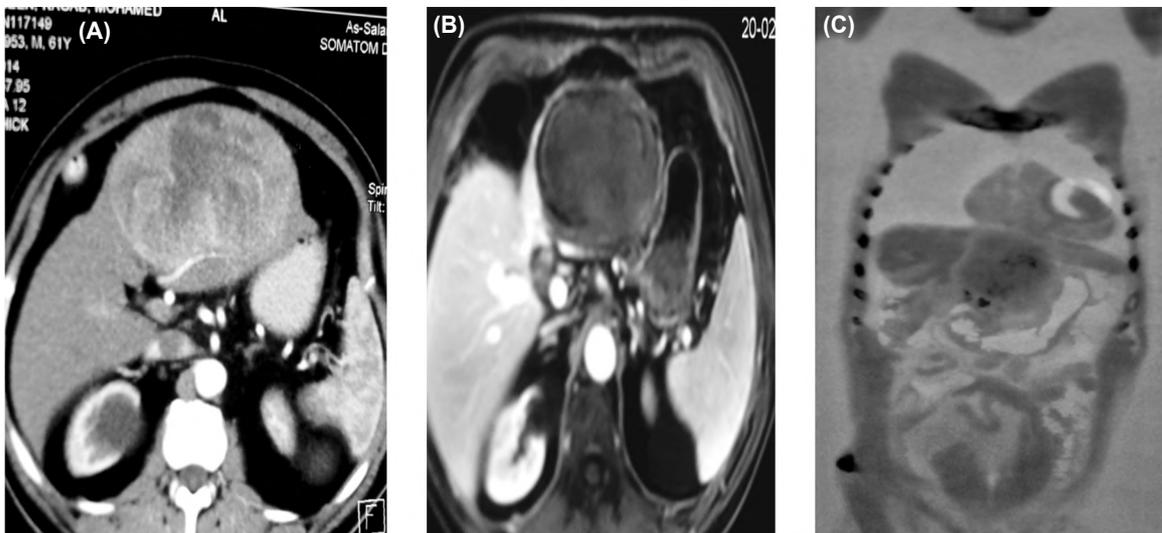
(A): CT scan showing large left hepatic lobe hypervascular lesion with contour bulge and central breakdown. (B): MRI scan 3 months post radioembolization showing no evidence of pathological tumoral enhancement. (C): Coronal PET/CT scan 6month post radioembolization decrease in the tumor size with no evidence of tumoral activity.
